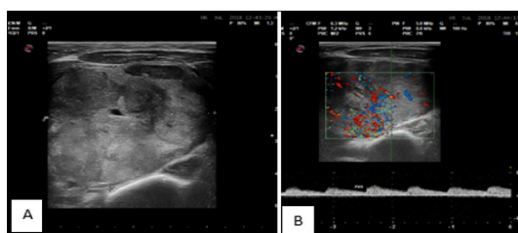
ATA Thyroid Nodule Sonographic Pattern-Intermediate Suspicious Lesion. Pathological diagnosis Follicular neoplasm – Bethesda-IV.
